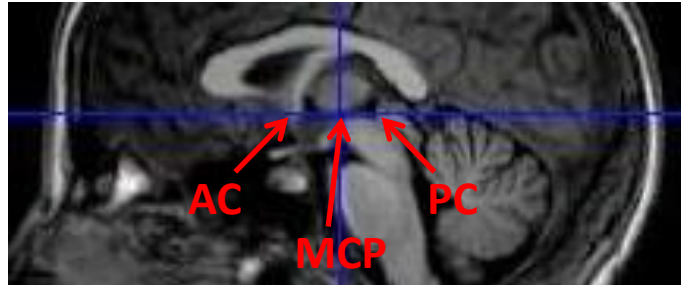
Localisation of AC, PC and MCP in a sagittal T1-weighted MR scan. AC = anterior commissure, PC = posterior commissure, MCP = midcommissural point.
